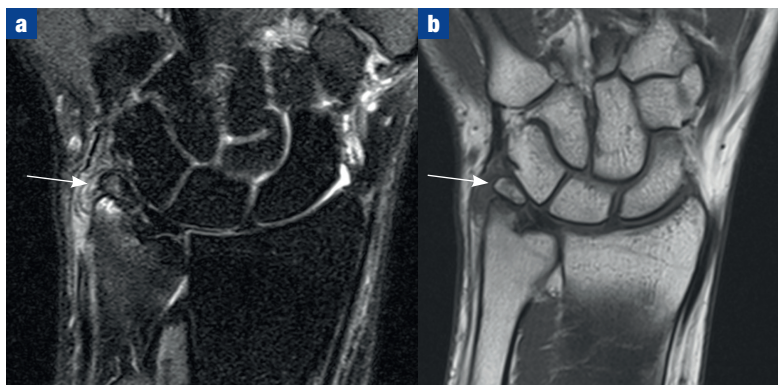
a. Magnetic resonance image coronal short tau inversion recovery (STIR) sequence of the wrist, demonstrating ulnocarpal impaction syndrome, with bone marrow oedema in the distal ulna and subtle oedema in the adjoining triquetrum (arrow). There is also surrounding soft tissue thickening and oedema. b. Coronal T1 sequences demonstrating ulnocarpal impaction syndrome, with a separate bony fragment at the styloid tip (arrow). This represents an old fracture with non-union.
